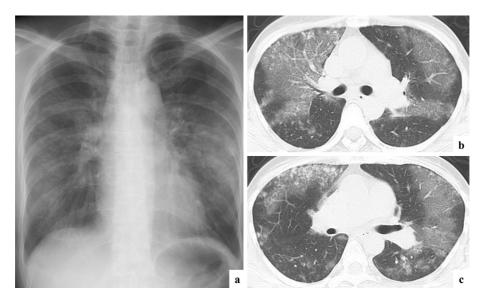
Chest imaging findings of case 2. Chest X-ray showed bilateral consolidation (a). Computed tomography showed bilateral ground-glass opacities and centrilobular nodules (b, c).
